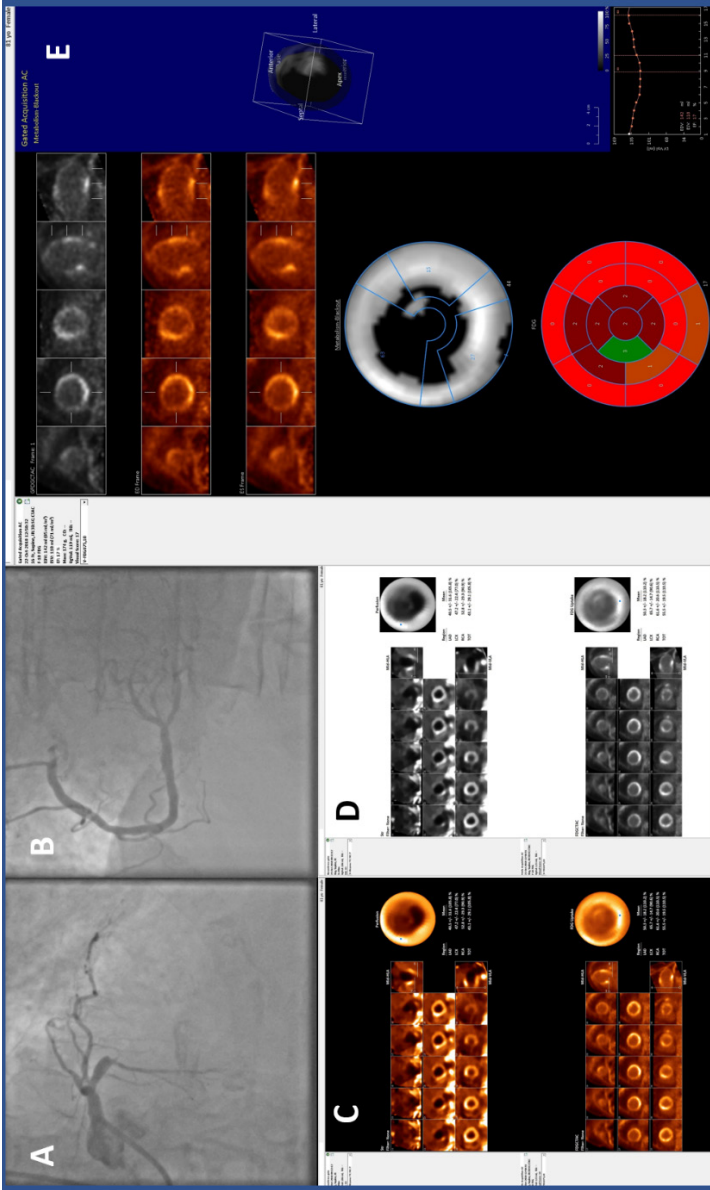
4. Viability study with SPECT MPI and ^{18}F -FDG PET. Coronary angiography showing (A) a proximal occlusion of the left anterior descending coronary artery and (B) patent right coronary artery. First study rest MPI with $^{99\text{m}}\text{Tc}$ tetrofosmin showing absent perfusion in the left anterior descending coronary artery territory ((C) and (D), upper rows). The second study with ^{18}F -FDG PET after glucose load shows some degree of preserved viability in the left anterior descending coronary artery territory second study ((C) and (D), lower rows). Gated PET (E) showing severe left ventricular dysfunction as seen from the time-activity curve ((E), lower right corner).
